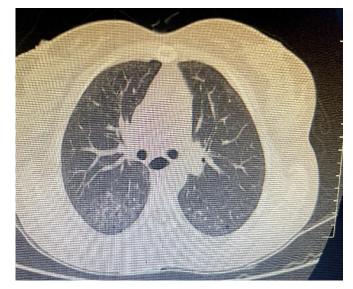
HRCT : Sub pleural ground glass attenuation with reticular opacities
